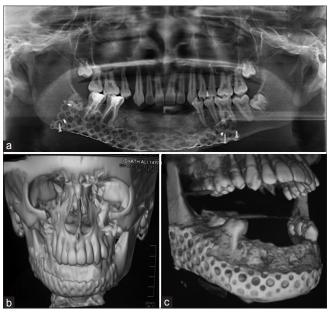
Postoperative (a) orthopantomogram at 10th month (b) computed tomography mandible at 10th month AP view (c) Mandible lateral view
